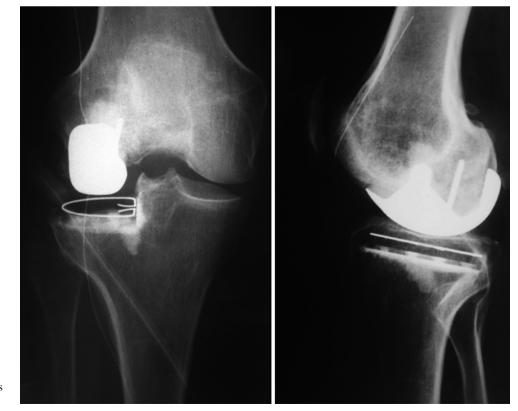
Postoperative X-rays (see case Fig. 28.32)
